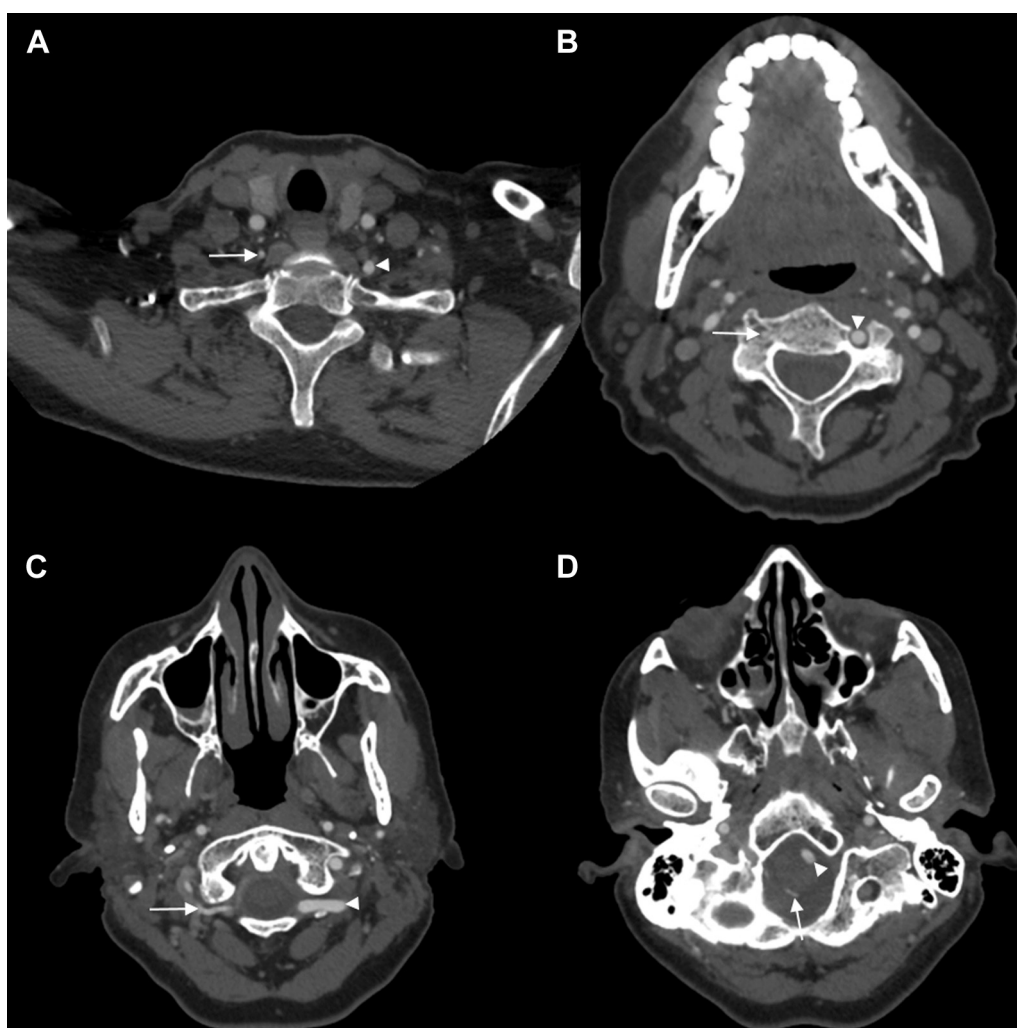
Axial section images of computed tomography angiography (CTA). Notice the marked size difference between the right vertebral artery (arrow) and left vertebral artery (arrowhead). (A) V1 segments of the vertebral arteries after they branch off the subclavian arteries at the level of the first thoracic vertebrae (T1). (B) V2 segments of the vertebral arteries as they ascend the transverse cervical foramina of C3. (C) V3 segments of the vertebral arteries as they emerge from the transverse cervical foramina and wrap around the posterior arch of C1. (D) V4 segments of the vertebral arteries within the posterior cranial fossa. The right vertebral artery has terminated as the posterior inferior cerebellar artery (arrow), and the left vertebral artery (arrowhead) continues to ascend anterior to the medulla to form the basilar artery.
